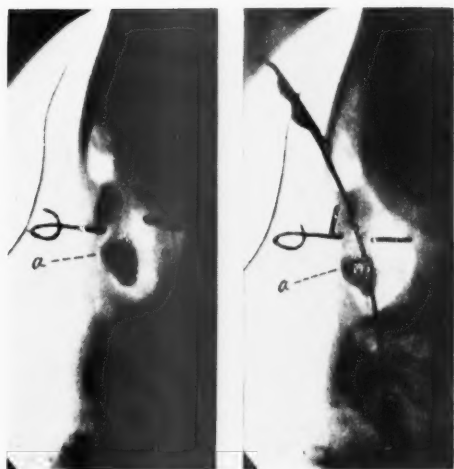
An x-ray taken in 1909 after injection of lacrimal sac with bismuth paste by Dr. A. E. Ewing.
